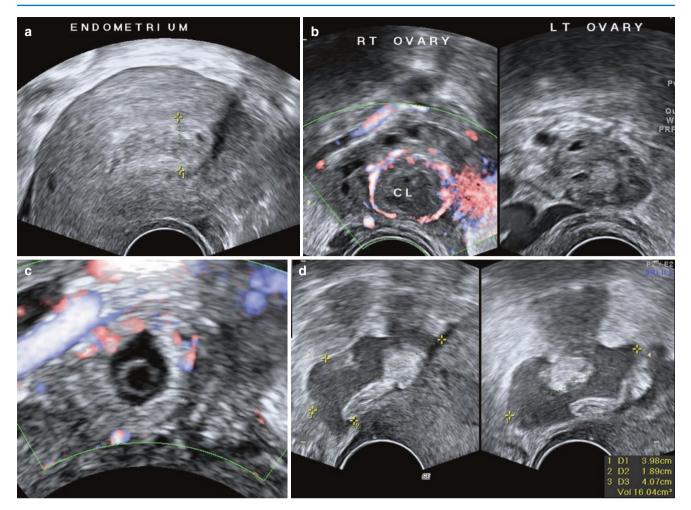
Findings in a case of an ectopic pregnancy. (a) Echogenic endometrium with a few tiny cystic spaces suggestive of decidualised endometrium. Endometrial cavity showing no evidence of intrauterine pregnancy. (b) Ovaries showing a corpus luteum in the right ovary. (c) Ectopic pregnancy mass showing a central cystic area (i.e., the gestational sac) surrounded by a thick hyperechoic trophoblastic tissue, showing peripheral flow on Doppler. Yolk sac is seen within the gestational sac. This is pathognomonic of an ectopic pregnancy, but is not always seen. (d) Turbid-free fluid suggestive of blood is seen in the peritoneal cavity
